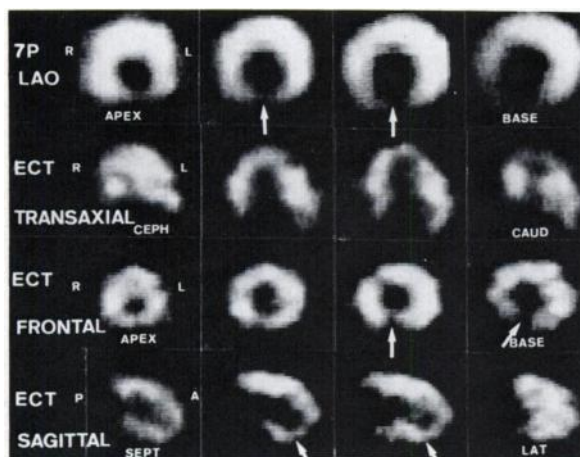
7P and SPECT images in patient with inferior-wall myocardial infarction. Sections in 7P proceed from apex to base. In SPECT, transaxial sections proceed from head to foot, frontal sections from apex to base, and sagittal sections from septal to lateral region. Perfusion defect in inferior wall is clearly seen (arrows)
